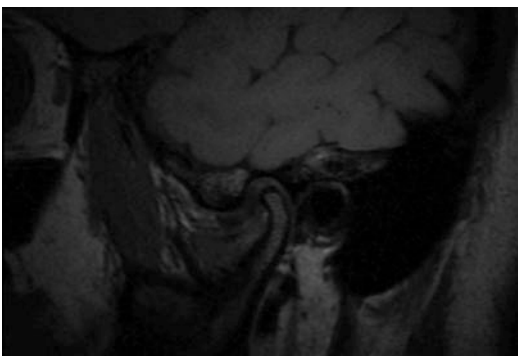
MRI of TMJ case
